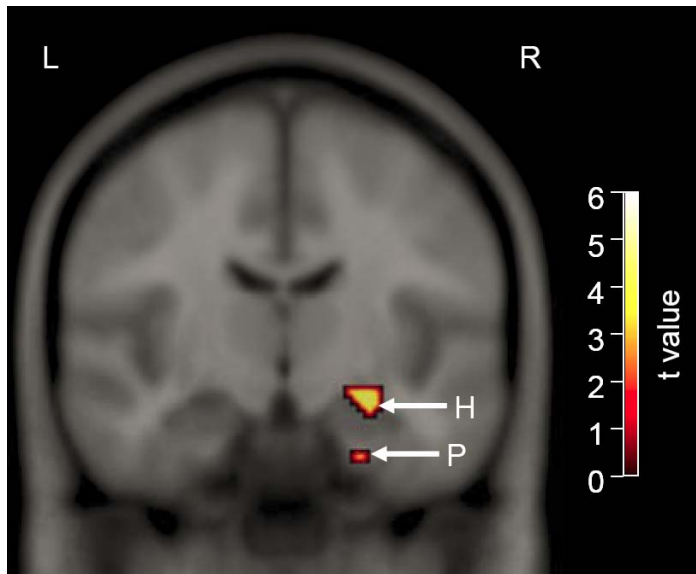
Overactivation of CT/TT carriers over CC carriers in the medial temporal lobe (Papassotiropoulos et al., 2006)
